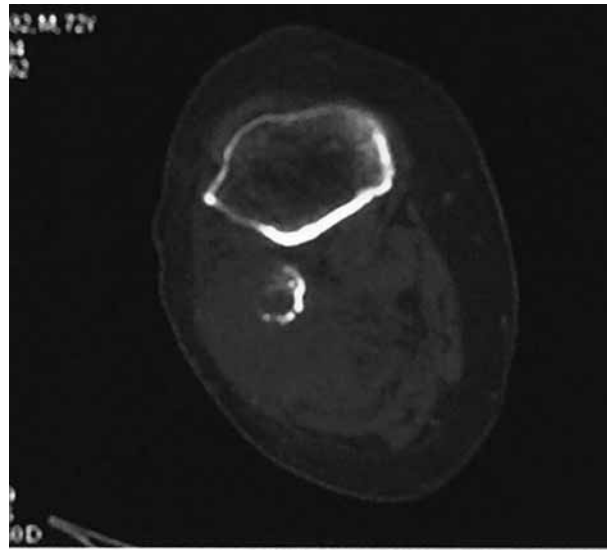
Computed tomography demonstrated cortical destruction in the fibula.
